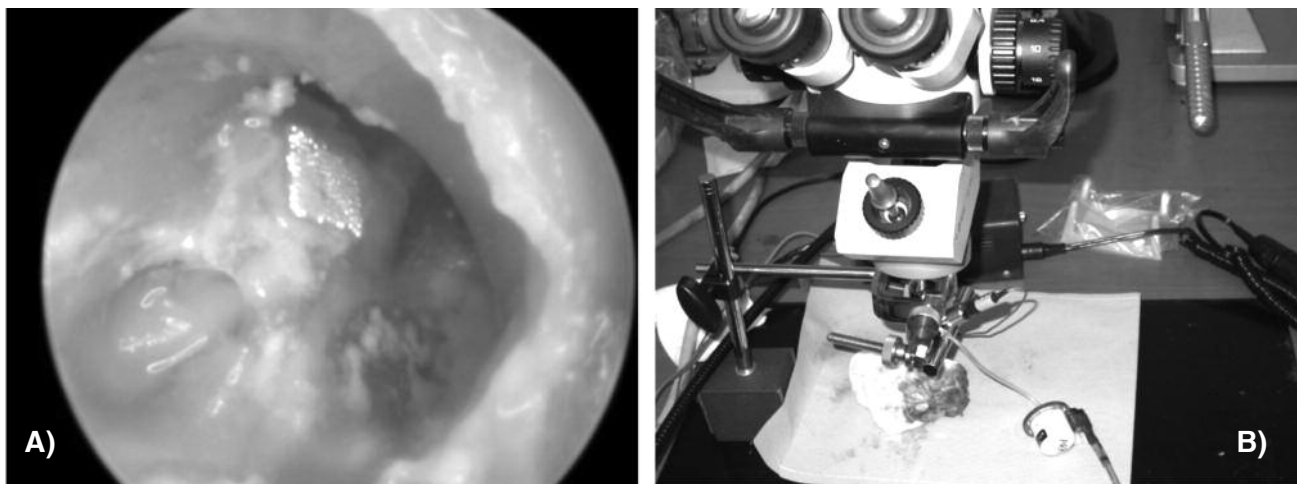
Reflection tape of the tympanic membrane over the manubrium (A). The velocity of the manubrium of the tympanic membrane over the interfaced cartilage was measured with a laser Doppler vibrometer (LDV) (B).
